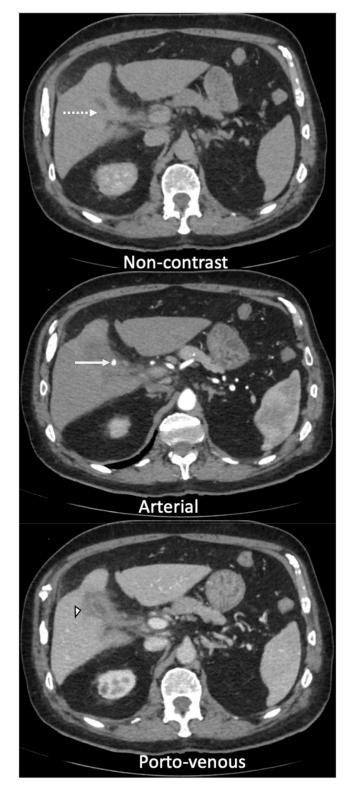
Axial reformatted noncontrast and postintravenous contrast computed tomography images in the noncontrast, arterial and portovenous phases with the dashed arrow demonstrating the gallbladder bed with no evidence of hyperdense focus, solid arrow demonstrating an enhancing focus representing a cystic artery pseudoaneurysm and arrow head demonstrating features gallbladder wall thickening with surrounding pericholecystic fluid and fat stranding.
